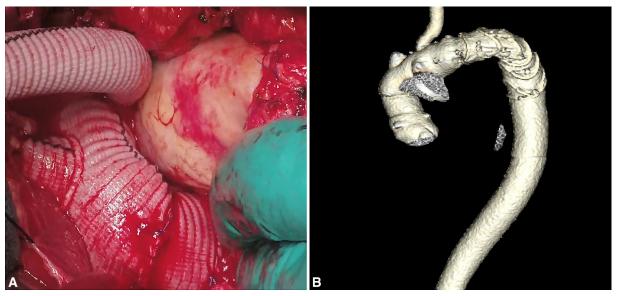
A, Intraoperative completed arch and Ross reconstruction. B, Predischarge computed tomography, with a 3-dimensional reconstruction showing the Ross, a sinotubular junction stabilization graft, hybrid arch repair with a Thoraflex graft.
